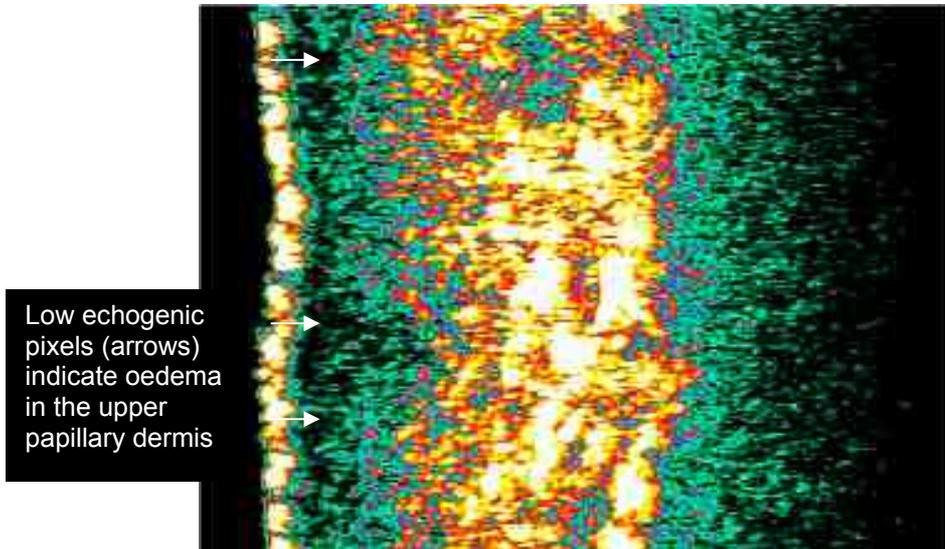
Acute dermal oedema during the cellulitic episode (20MHz ultrasound scan)
